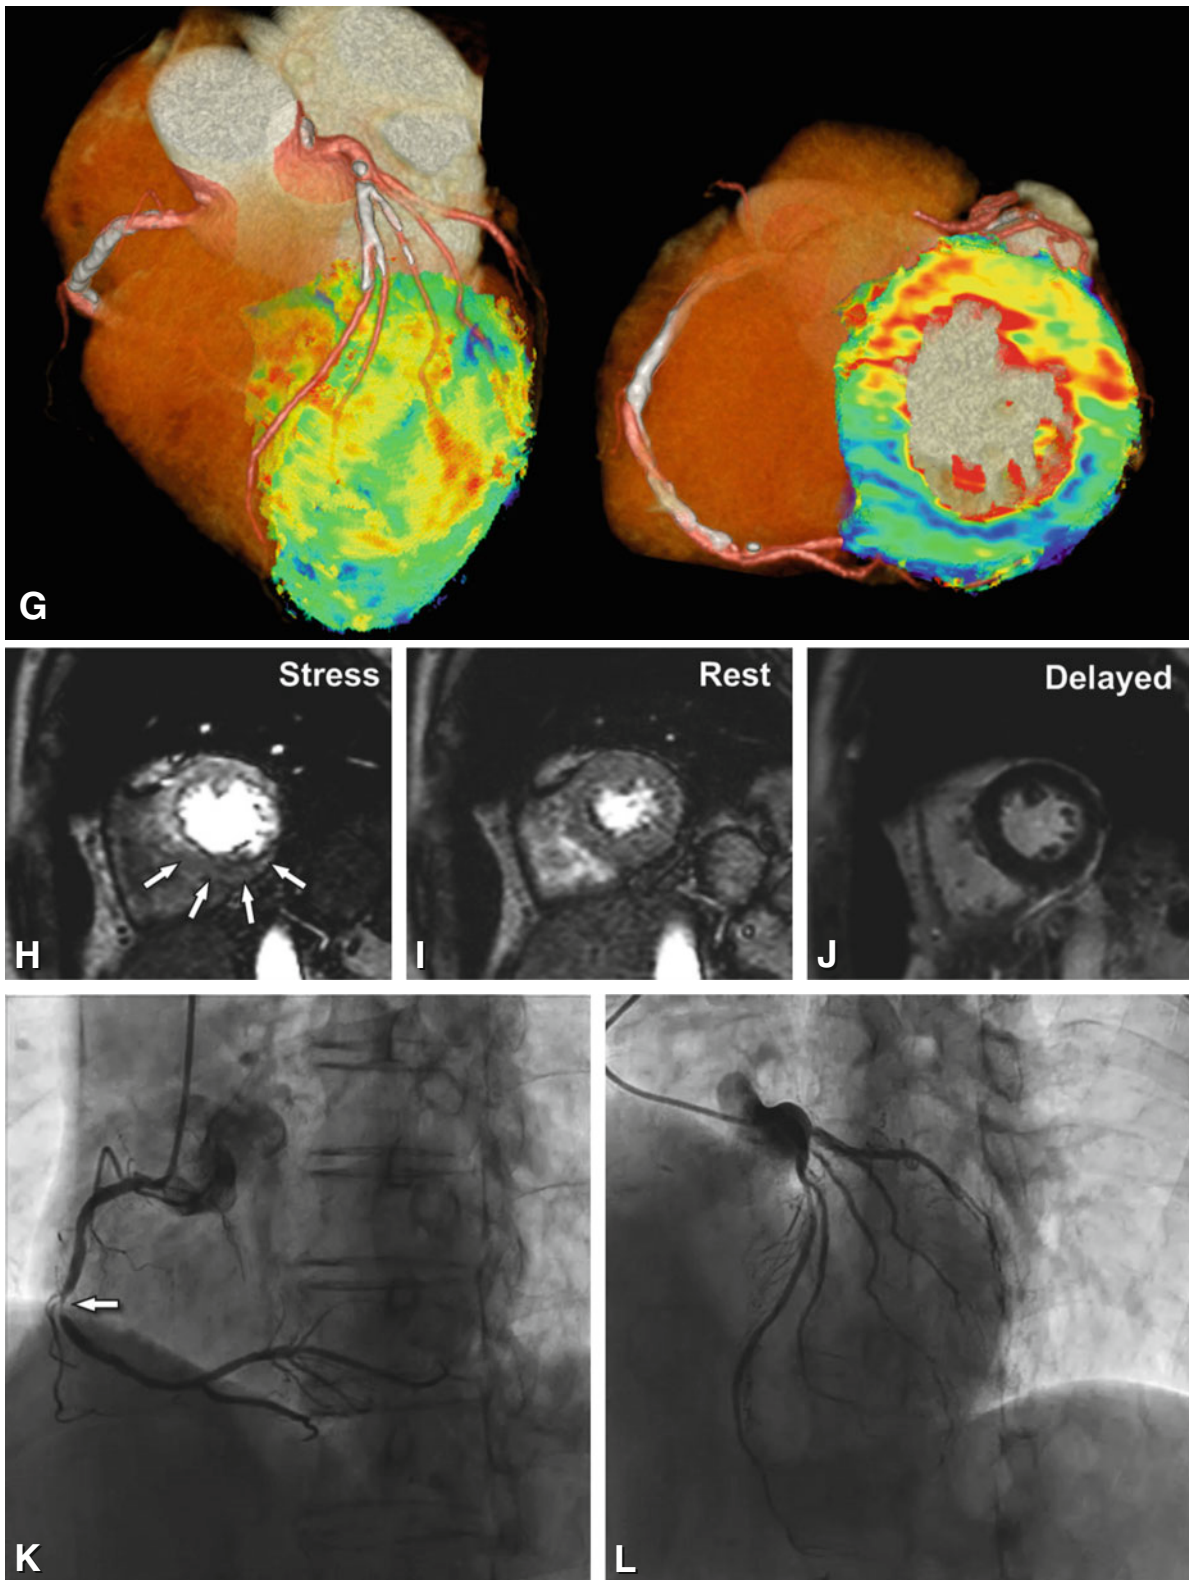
Comprehensive cardiac study using second-generation dual-source CT in a 69-year-old female with diabetes mellitus and angina pectoris. Presence of heavily calcified plaques precluded CT assessment of coronary artery stenosis (Panels A–C). Stress dynamic CTP of 10 frames acquired intermittently over a period of 30 s demonstrated severe perfusion deficit in the inferior wall (*arrows in Panel D*). Quantitative analysis of the dynamic CTP indicated higher myocardial blood flow (100 ml/min/g) in the anterior wall compared with the inferior wall (67 ml/min/g, Panel E). There was no delayed enhancement on the late scan (Panel F)
